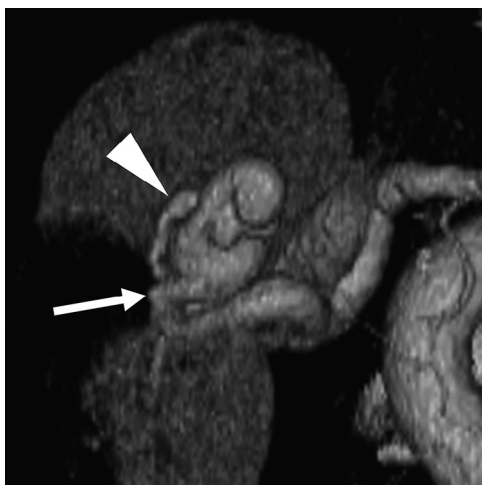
3-Dimensional computed tomography angiography revealed a large aneurysmal-type renal arteriovenous fistula with a single feeding artery (arrow) and a single draining vein (arrowhead).
